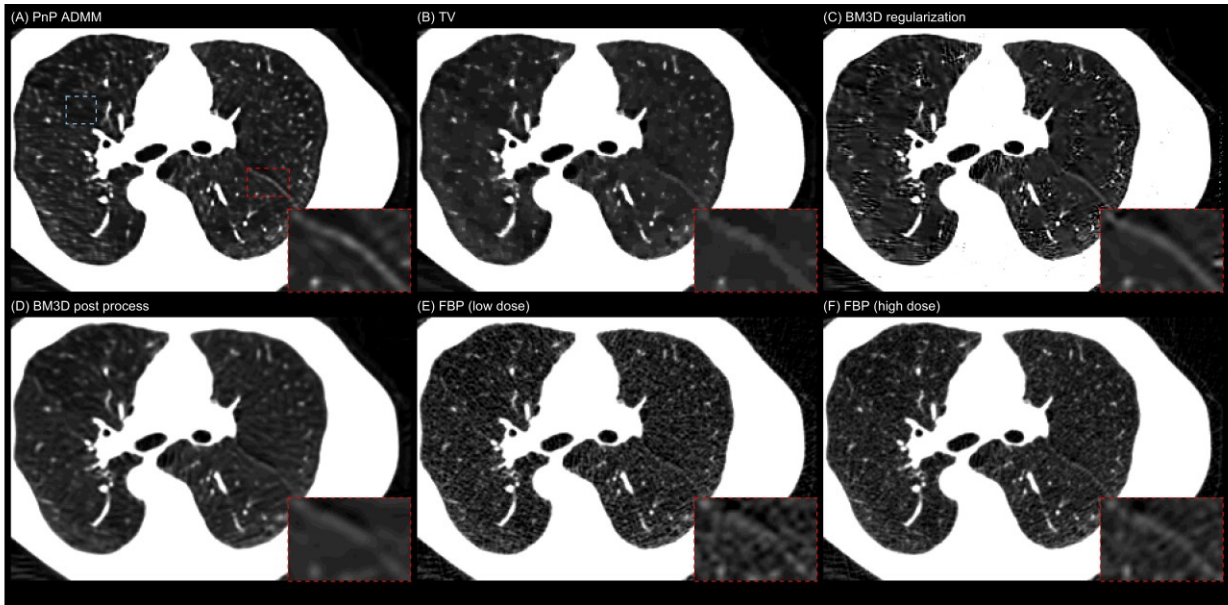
Reconstructed image of the lung patient #1 with zoomed-in view of the fissure line using (A) Plug-and-Play ADMM, (B) TV, (C) BM3D regularization, (D) BM3D post process and (E) FBP from low dose CT (50% dose), and (F) FBP from standard dose CT data. The conformal region indicated by the blue rectangle is used for standard deviation evaluation in Table 2-4.
